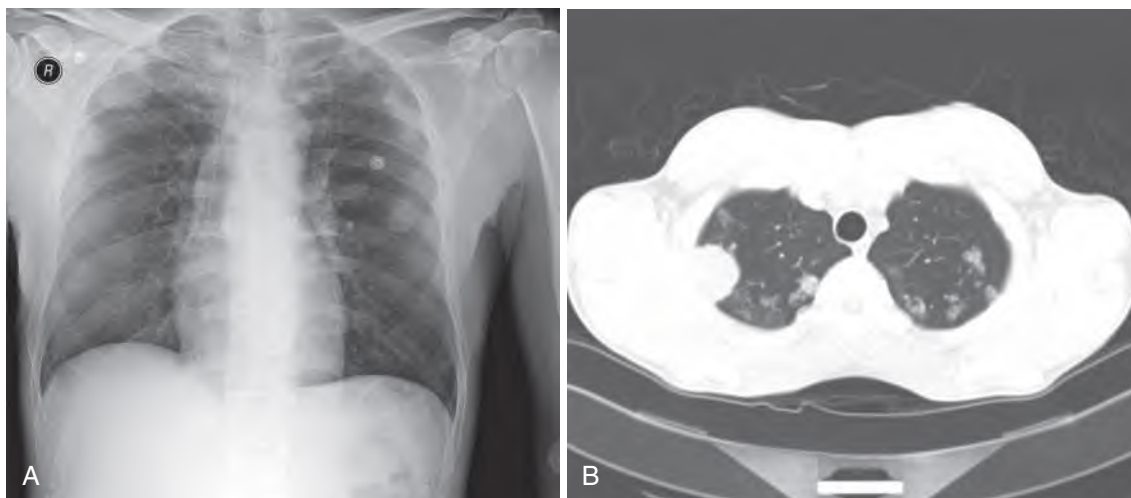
(A) This 48-year-old white male with fever, nonproductive cough, and frontal headache has an extensive travel history, including military service in Southeast Asia, the Philippines, Australia, and California. Chest radiograph reveals multiple bilateral, nodular pulmonary lesions. Both serum and cerebrospinal fluid (CSF) and cryptococcal antigen assay were positive, and CSF eventually revealed *Cryptococcus gattii*. (B) A computed tomography scan of the chest in the same patient reveals multiple parenchymal, poorly defined nodules and one large pleural-based nodule typical for *C. gattii* pulmonary infection.
